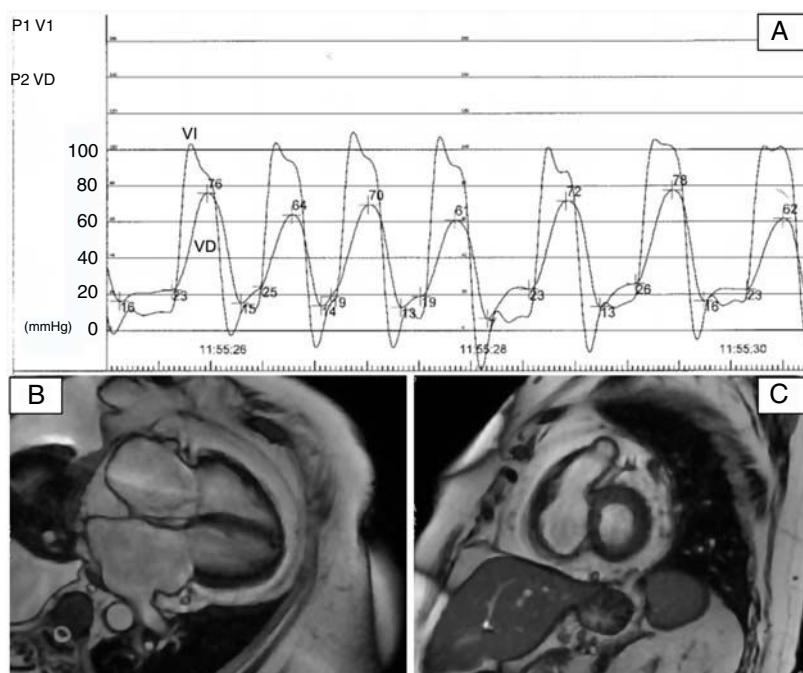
A, Cardiac catheterization showing a left ventricular dip and plateau pattern with elevation and equalization of end-diastolic pressures in both ventricles. B and C, Steady-state free precession cardiac magnetic resonance imaging 4-chamber view (B) and short-axis (C) showing abundant epicardial fat accumulation.
